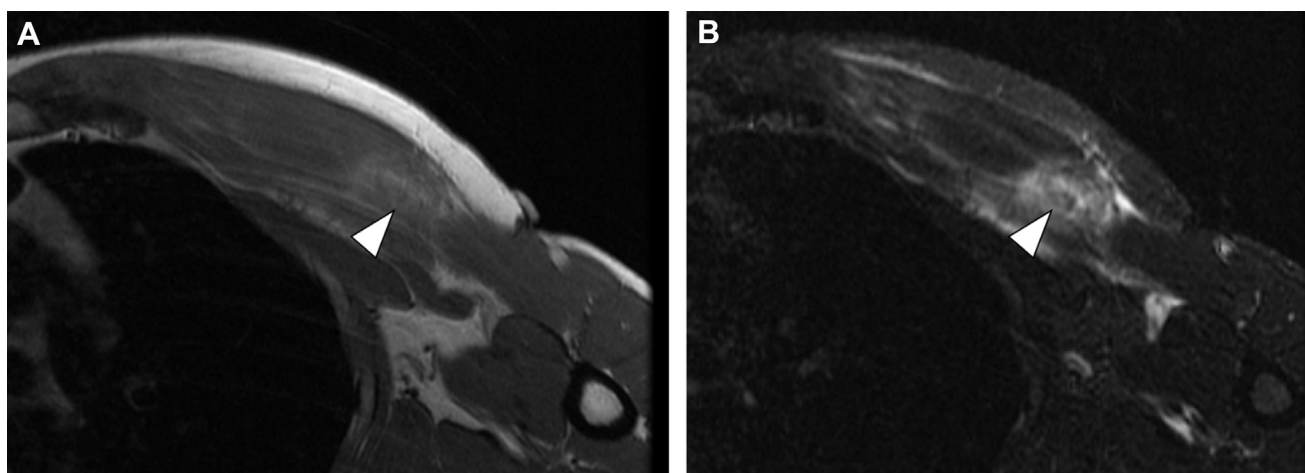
(A, B) Left shoulder magnetic resonance imaging showing complete rupture and retraction of sternal head of pectoralis major tendon at humeral insertion (*arrowheads*).
